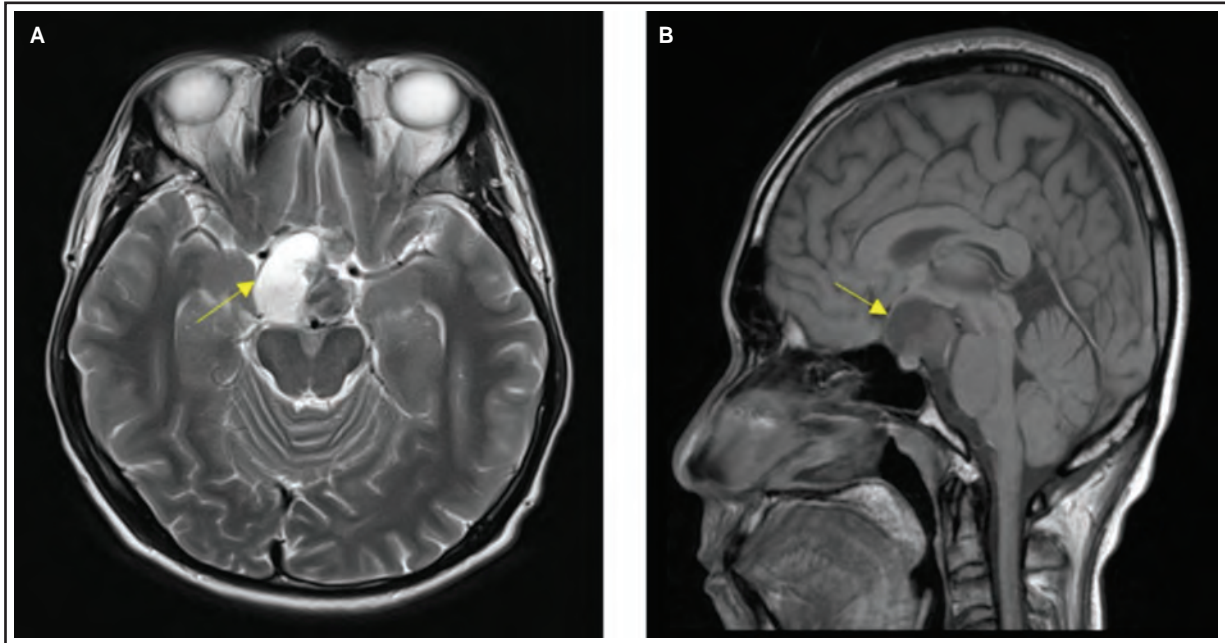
Picture on the left (a) showing T2 weighted MRI brain axial view. The mass can be see via the yellow arrows. Picture on the right (b) featured MRI brain sagittal view FLAIR.
